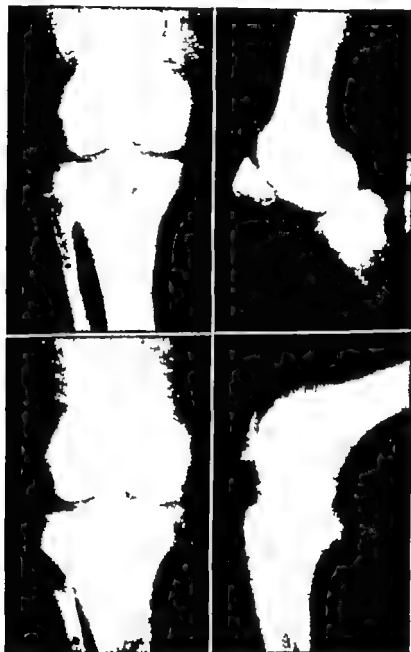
(*Top*) Right knee joint of a female 51 years old. When first examined on May 8, 1952, the chief complaint was pain in the inner aspect of the knee joint following a twisting injury. Physical and roentgenographic examination exhibited no evidence of a neuro-arthropathic joint. (*Bottom*) The same knee 6 months after meniscectomy. The joint is completely disrupted and reveals all the roentgenographic features of Charcot joint. The patient's serology, both blood and spinal fluid, was positive. This is the atrophic variety of Charcot joint.
